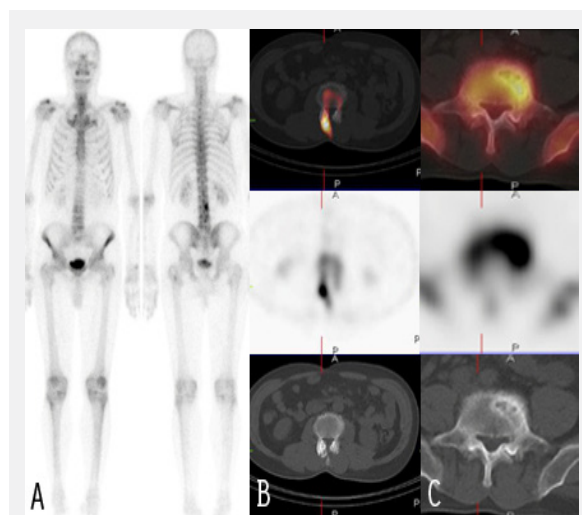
A 62-year-old male patient with a history of prostate carcinoma had osteoblastic activity in the right half of the L3. vertebra on planar images (A). SPECT-CT images showed degenerative changes in the L3 vertebra facet joint (B). In addition, SPECT images showed an increased osteoblastic activity in the left half of the L5. vertebra corpus; CT findings were consistent with degenerative changes (C).
